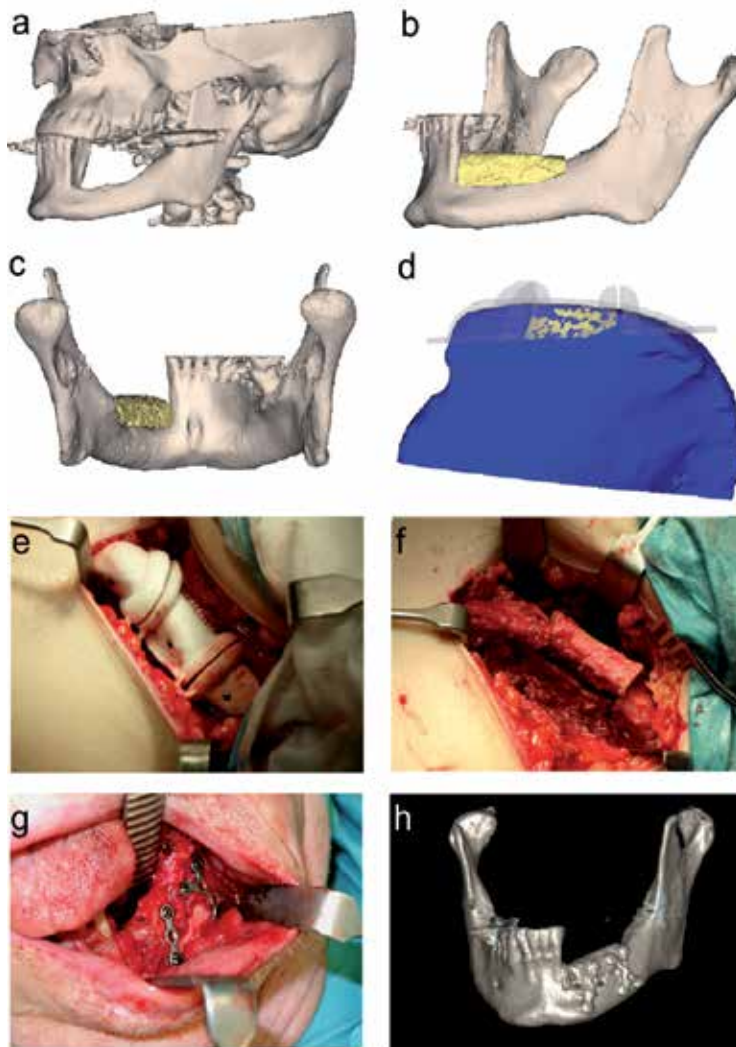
Case 1. (a) 3-D CT shows the left mandibular defect. (b) and (c) Virtual reconstruction of osseous defect. (d) Virtual iliac crest with planned cutting guide and transplant. (e) Intraoperative positioning of the cutting guide. (f) Harvesting of the iliac crest bone. (g) The transplant inset and fixed. (h) Postoperative 3-D CT findings with iliac crest for mandibular augmentation.
